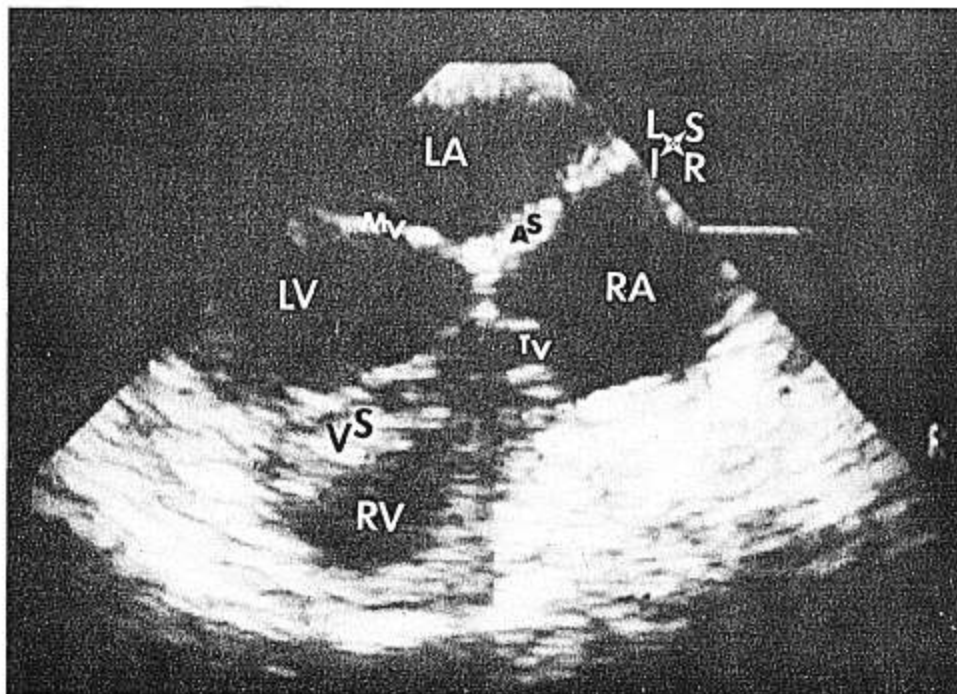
Normal 4-chamber cardiac view as imaged by the transesophageal transducer. All four cardiac chambers are imaged simultaneously from the postero-inferior surface of the heart. RV = right ventricle; LV = left ventricle; VS = ventricular septum; TV = tricuspid valve; LA = left atrium; RA = right atrium; and AS = atrial septum, [L = left, R = right, S = septum (basal), I = inferior (spinal) cardiac orientation].
